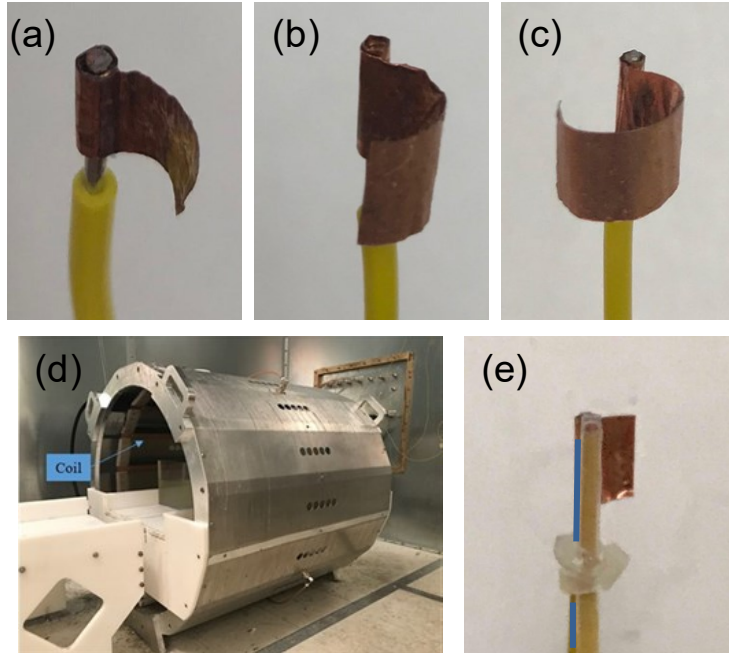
Lead electrodes used in measurements (a) a 0.25-circle electrode, (b) a 0.5-circle electrode, and (c) a 0.75-circle electrode. The 1.5 T MRI coil system for the thermal measurements is shown in (d), and (e) shows the optical-fiber thermal probe (blue line) connected to the generic electrode.
